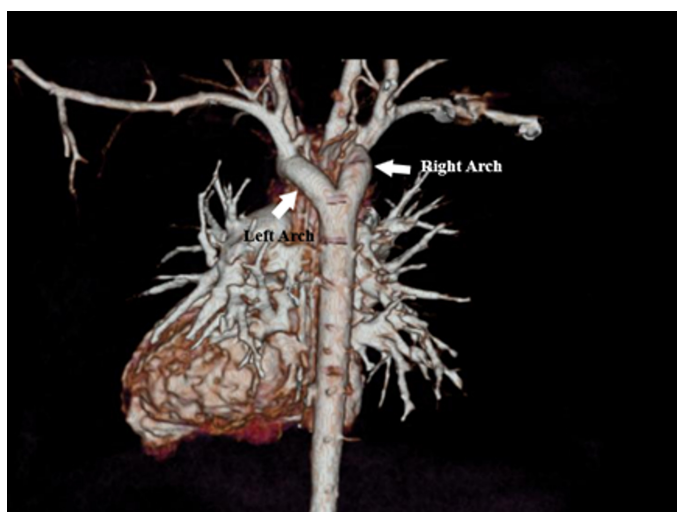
A 3-dimensional volume-rendered image of the double aortic arch seen in contrast-enhanced computed tomography in posteroanterior position.
